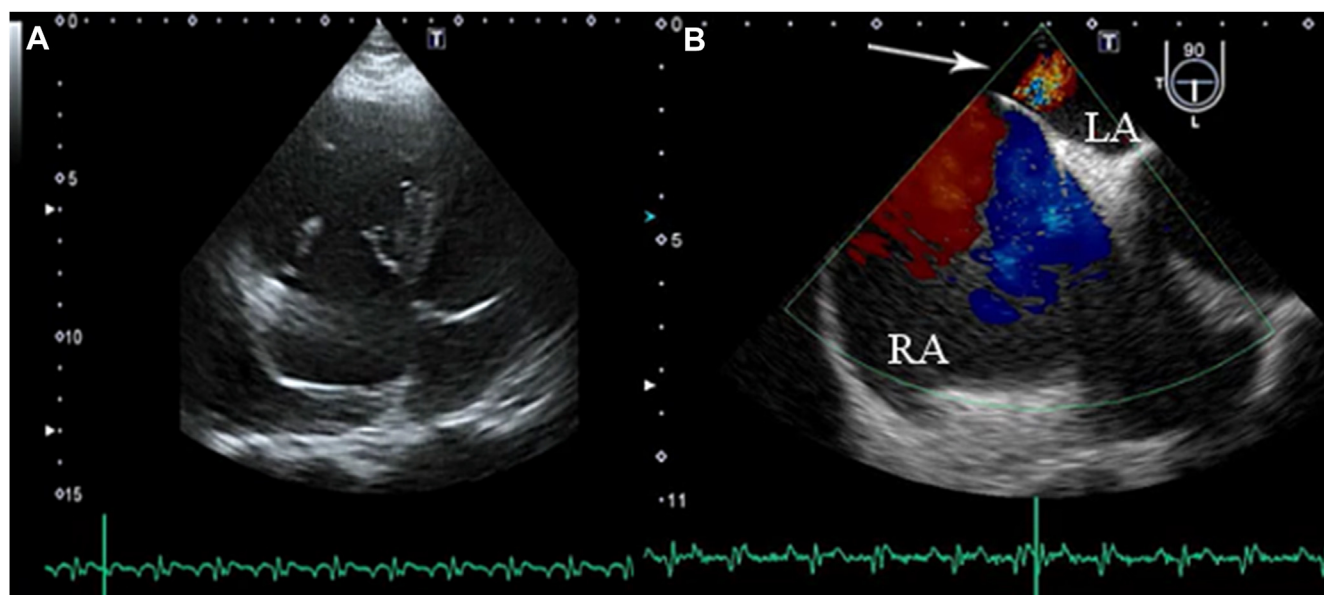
(A) Transthoracic echocardiography showed a markedly dilated right atrium (RA) and ventricle. (B) Transesophageal echocardiography with color Doppler showed a continuous right-to-left shunt through an iatrogenic atrial septal defect (arrow). LA, left atrium.
